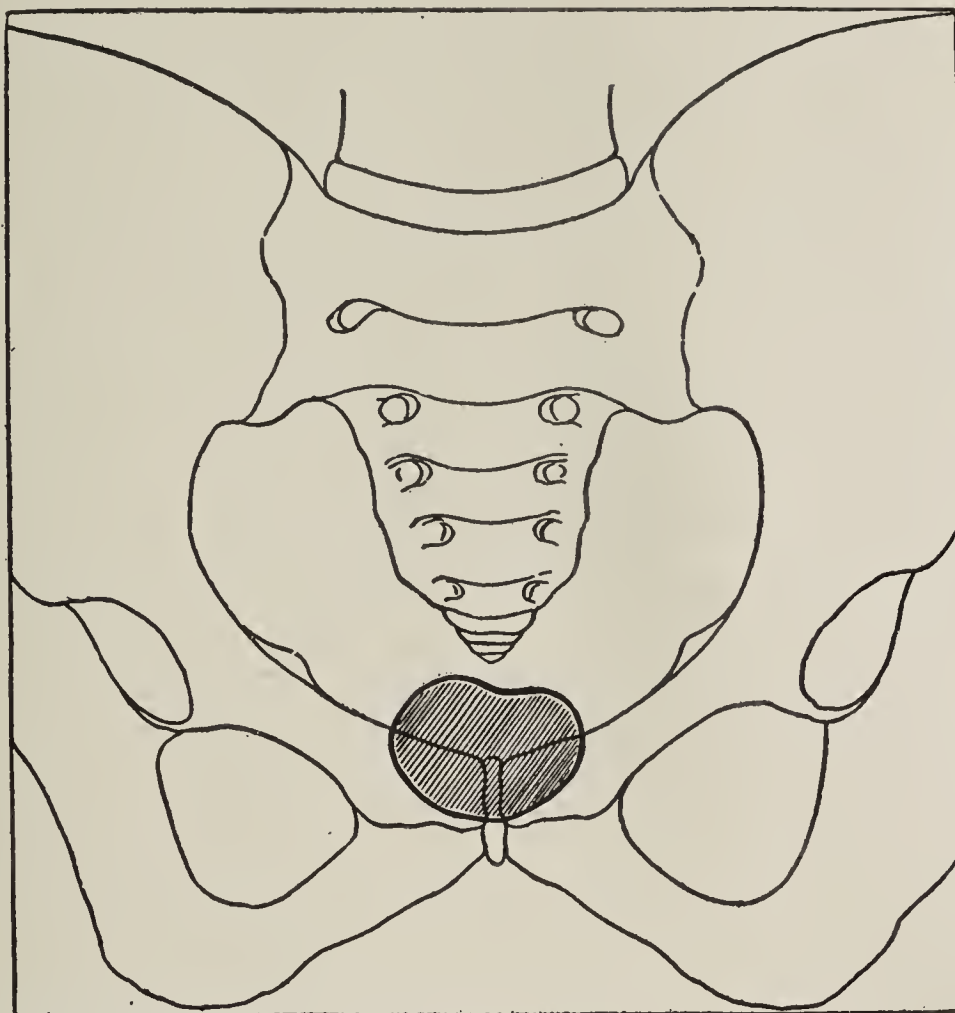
B.—SKETCH INTERPRETING THE RADIOGRAPH SHOWN IN FIG. 567 A.
